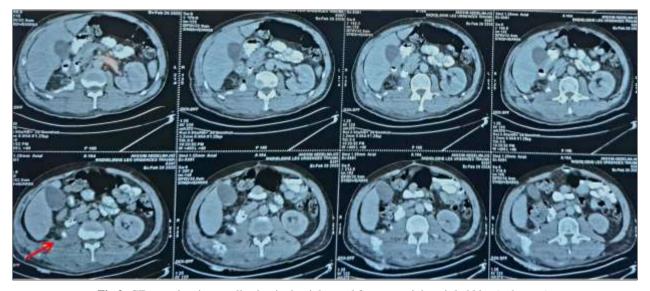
CT scan showing a collection in the right renal fossa containing air bubbles (red arrow).
